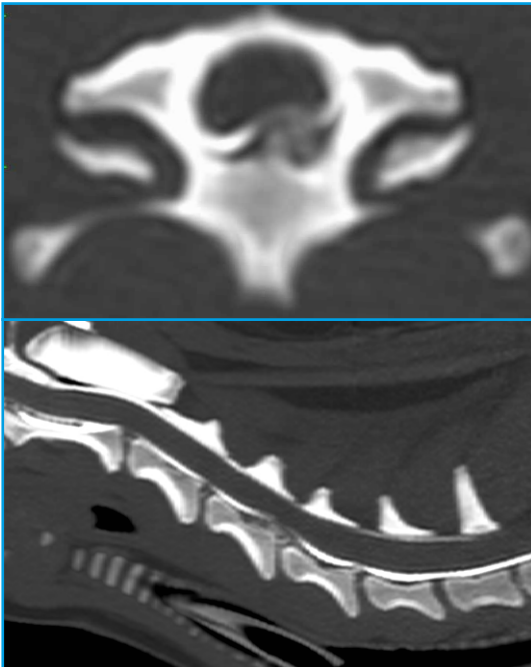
CT myelogram C4-C5.
